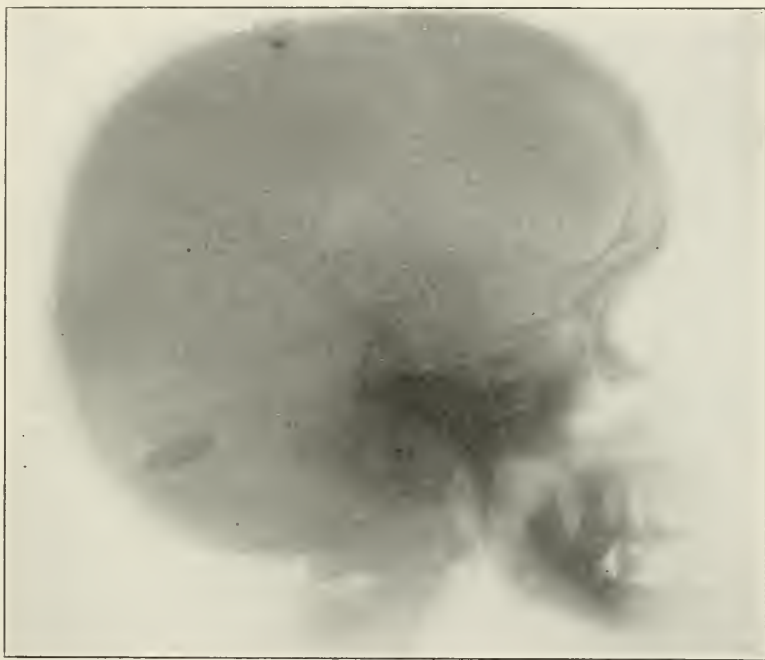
Skiagram in case of Pvt. J. S. Powell, Co. "K" 9th Inf., showing a Krag-Jorgensen bullet lodged on the tentorium. Army Med. School collection X-ray Laboratory.
